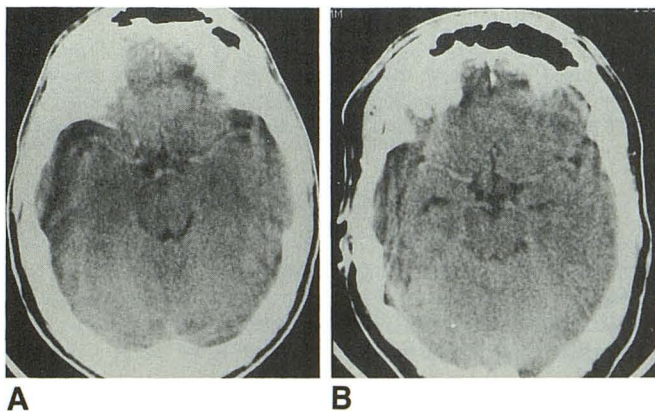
A and B, CT scans of two patients who recently had used cocaine intranasally show bilateral enhancement of middle cerebral arteries (A) and of middle, posterior, and anterior cerebral arteries (B).
